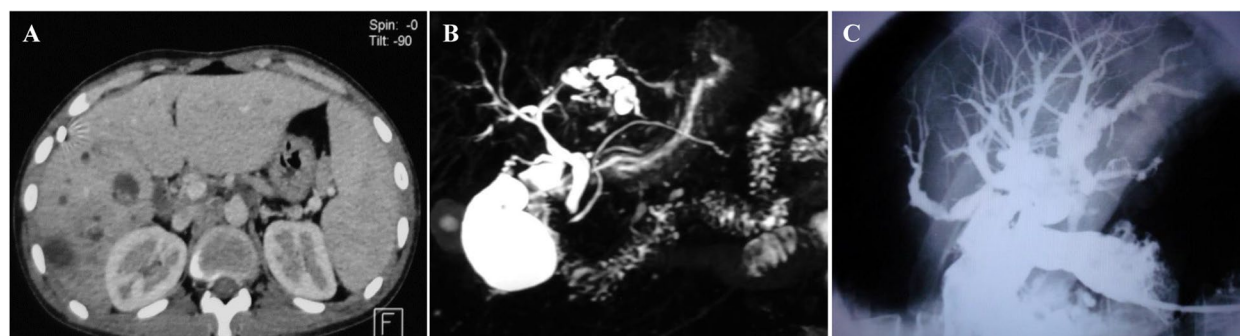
A Abdominal CT scan revealing hypodense lesions in segments VI and VII, along with multiple cystic formations in the right lobe, with the presence of a dot sign (arrow). B MRCP showing dilation of the left intrahepatic bile ducts (arrow) with the presence of intrahepatic and gallbladder stones. C Intraoperative cholangiography showing dilation of the left intrahepatic bile ducts with numerous calculi
